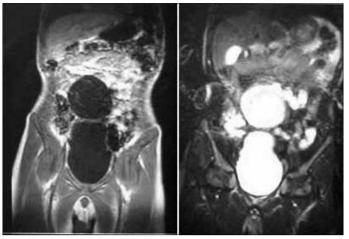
Contrast renal MRI showed a isointense diverticulum located in superior and anterior of bladder.
